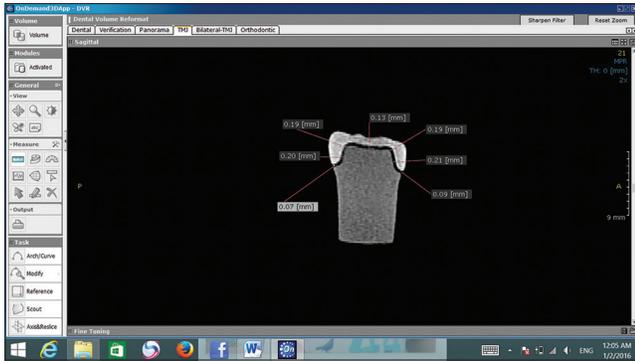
Measuring points on a cone-beam computerized tomography image
